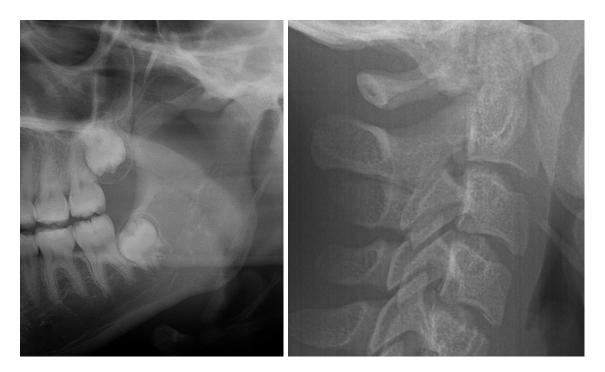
Cropped panoramic and cephalometric radiographs of a BSA female.
